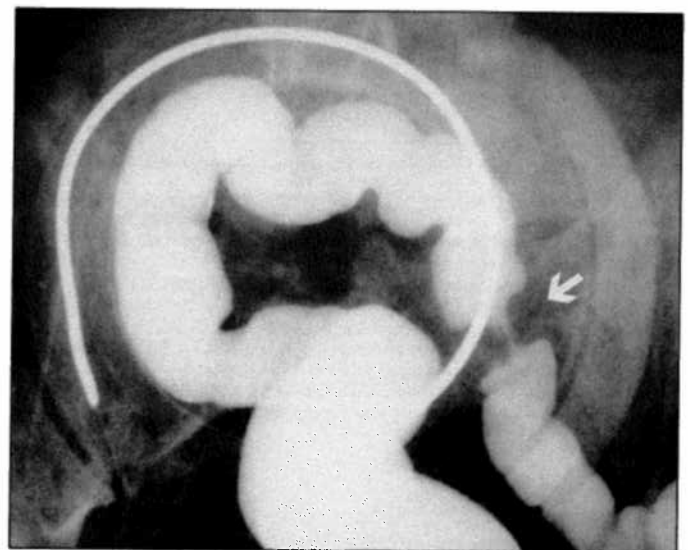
This spot compression radiograph demonstrates an area of narrowing in the sigmoid colon (arrow) with definite overhanging edges and sharp transition from the normal and abnormal bowel.
